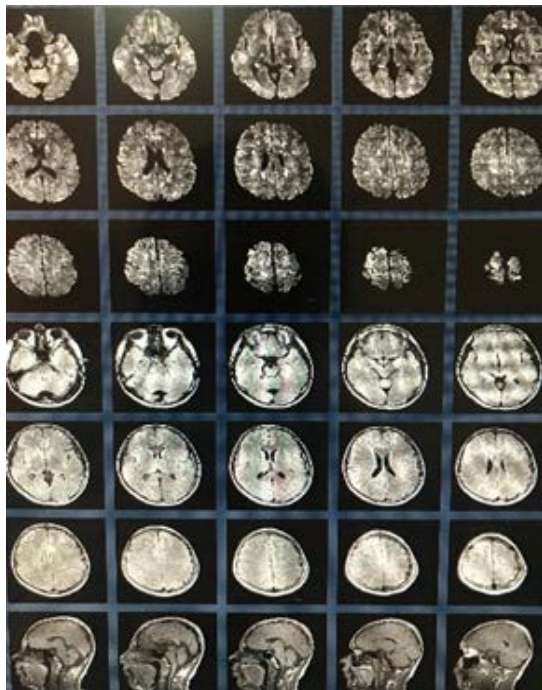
The usual sequences were obtained in the axial, sagittal and coronary planes through MRI scan.
